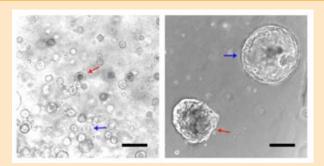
Human pancreatic ductal adenocarcinoma organoids from endoscopic ultrasound guided biopsies. Normal pancreatic organoids (blue arrow) with cystic morphologies and tumour organoids (red arrow) with filled morphologies. (Left) Day 8 (Right) Day 27. Scale bars, 200um.
